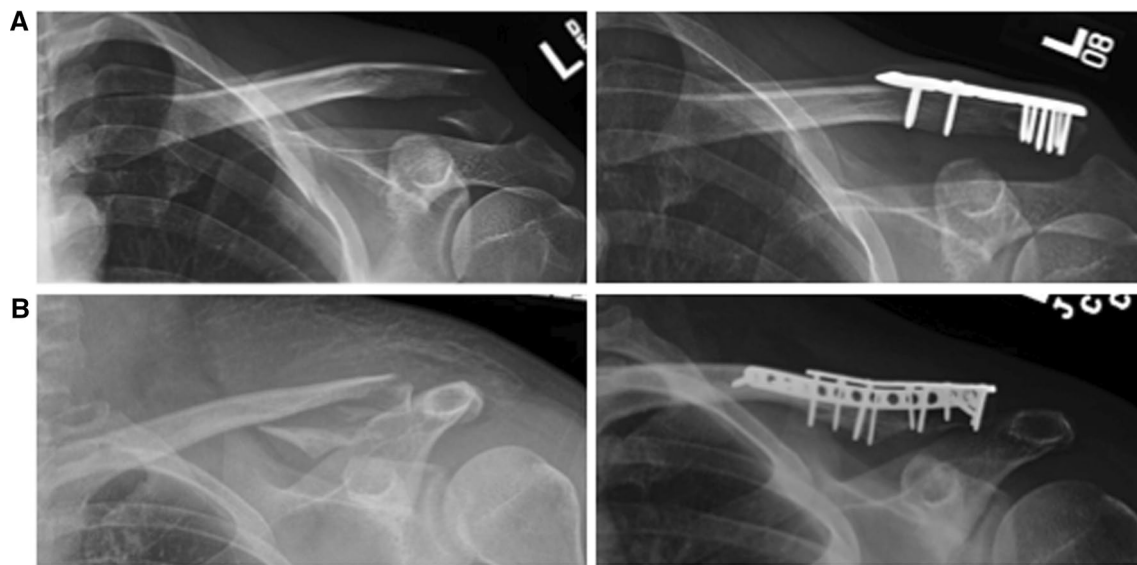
Radiographs demonstrating a series of unstable distal clavicle fractures and successful union after treatment with a precontoured locking plate and b dual mini-fragment plates
